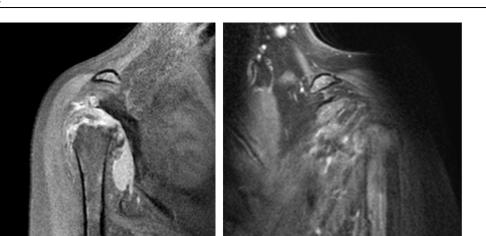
Bilateral humerus MRI of patients. MRI showed complete bone resorption of left humerus head and neck and scapula's glenoid process and partial bone resorption of right humerus. Bilateral shoulder muscles widespread lipoid atrophy was seen.
